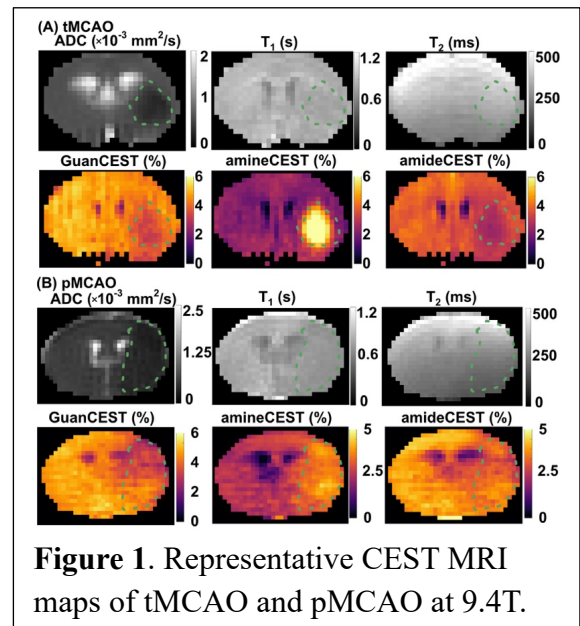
Representative CEST MRI maps of tMCAO and pMCAO at 9.4T.
